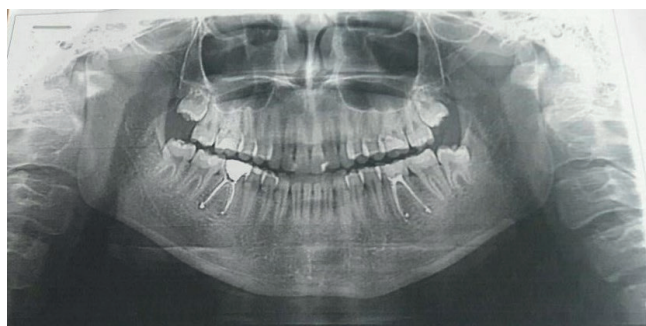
Orthopantomogram of patient M., 20 years old, before tooth extraction. Difficult eruption of 4.8 teeth. Semi-retention 1.8, 2.8, 3.8 teeth
